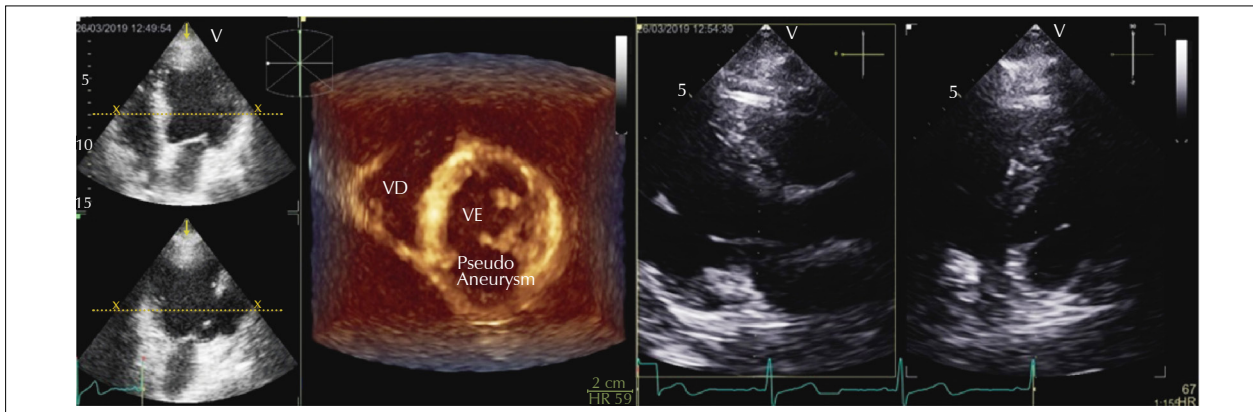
Transthoracic echocardiogram.
